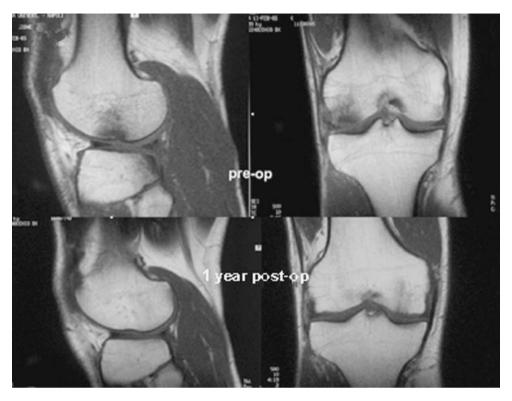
Pre-operative and post-operative MRI images
